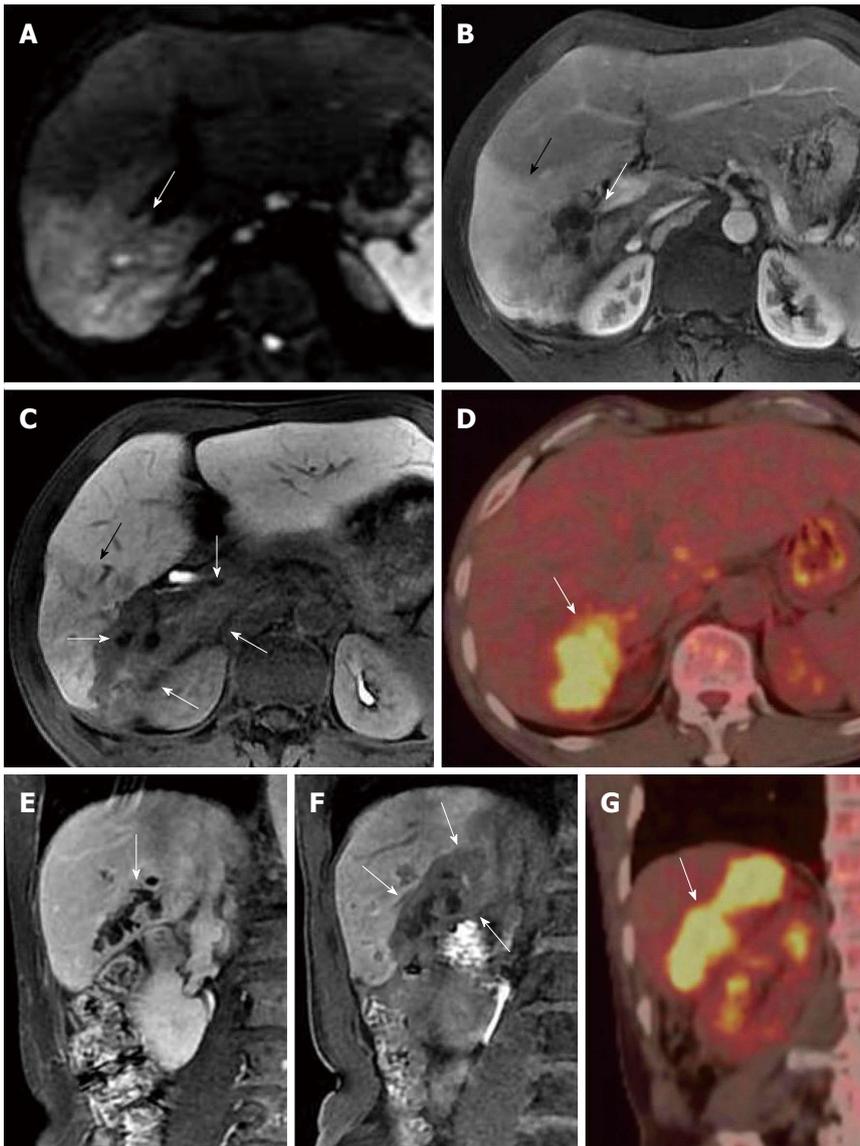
Fifty-six-year-old male patient with infiltrative intraductal papillary mucinous neoplasm of the bile duct (case 5). A: Diffusion-weighted imaging showed a hyperintense area in segment VI of the liver (white arrow); B: Gadolinium (Gd)-diethylenetriamine-pentaacetic acid (DTPA)-enhanced magnetic resonance imaging (MRI) in the portal venous phase showed marked enhancement in the anterior subsegment (black arrow) and a slightly hypointense area in the posterior subsegment of segment VI (white arrow); C: Gd-ethoxybenzyl (EOB)-DTPA-enhanced MRI in the hepatobiliary phase revealed bile duct dilatation in the posterior subsegment of segment VI without contrast filling. The hypointense area around the dilated bile duct indicated tumor infiltration to the surrounding tissue (white arrows). The anterior subsegment of segment VI with a slightly decreased low signal intensity suggested an inflammatory change (black arrow); D: Positron emission tomography-computed tomography (CT) confirmed the tumor in the posterior subsegment of segment VI with substantial uptake of fluorodeoxyglucose (white arrow), suggesting active tumor metabolism; E: Coronal Gd-DTPA-enhanced MRI in the equilibrium phase showed serrated changes in the bile duct wall of the posterior subsegment of segment VI, and the extra-biliary tumor infiltration was not well identified (white arrow); F: Gd-EOB-DTPA-enhanced MRI in the hepatobiliary phase showed bile duct dilatation in the posterior subsegment of segment VI without contrast filling. The tumor infiltration surrounding the dilated bile duct was hypointense and well defined (white arrows); G: Fluorodeoxyglucose uptake by the tumor (white arrow) was also shown in the posterior subsegment of segment VI during positron emission tomography-CT.
